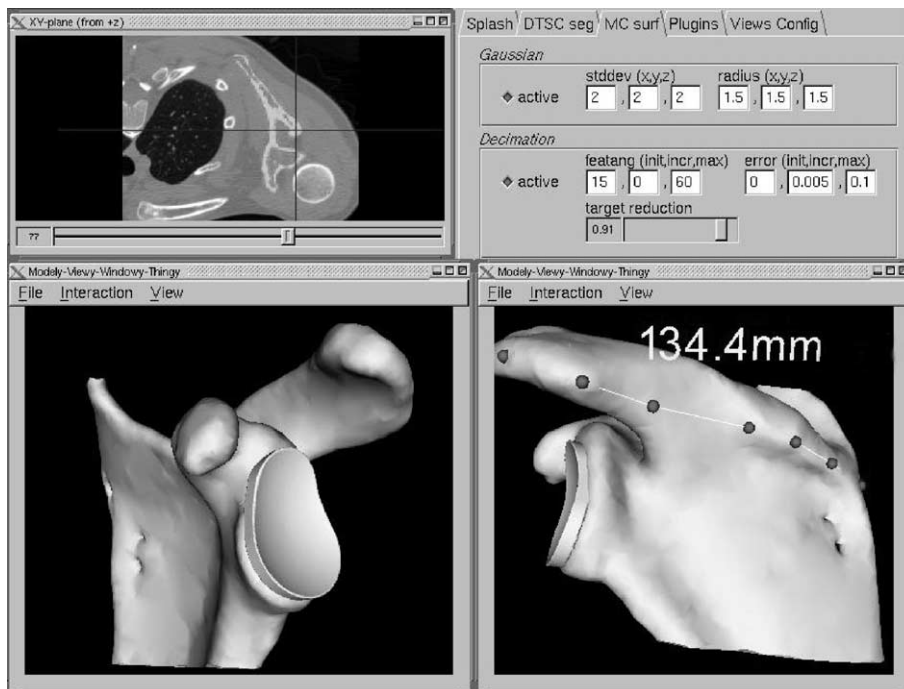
Screen layout of DSCAS. In the upper left corner, a single CT slice of the shoulder is displayed. In the lower left corner, a scapular surface reconstructed from in vivo CT data is shown with an “implanted” glenoid component. On the right, this same assembly has been used to measure the length of the scapular spine.
